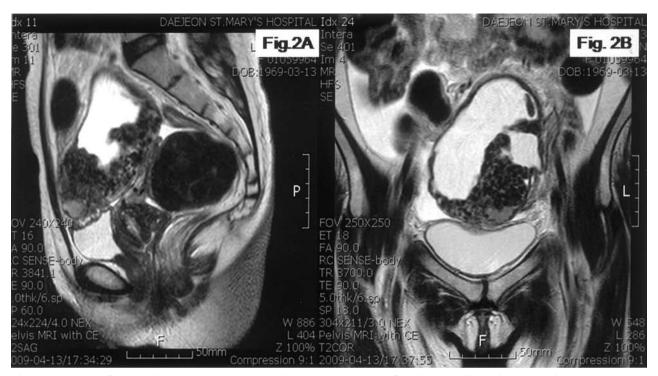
MRI of the pelvis shows a show huge ovarian tumor composed of cystic and solid portions on sagittal T2WI (A) and coronal T2WI (B). The cystic portion shows high signal intensity and the solid portion shows heterogeneous low signal intensity.
